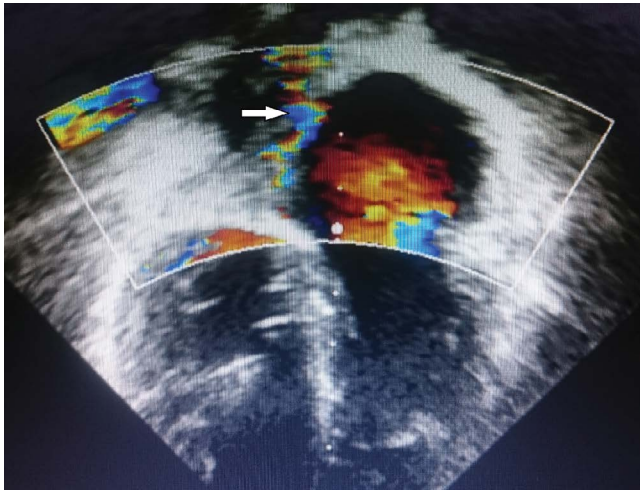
Echocardiographic picture showing the free drainage of the coronary sinus into the right atrium (arrow).
